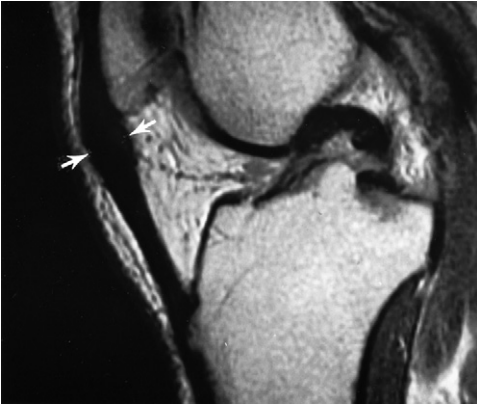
Patellar tendonosis. Sagittal T1-weighted image demonstrates marked thickening (arrows) of the tendon at the patellar attachment.
